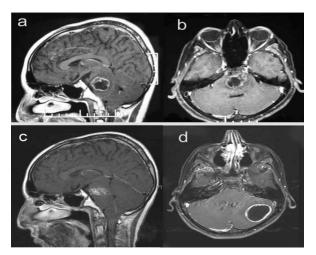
_Images before radiotherapy (a, b):Mid-sagittal (a) and axial (b) contrastenhanced T1-weighted MRIs show a lesion with wellcircumscribed heterogeneously contrast enhancement which was 30 mm in diameter. Images obtained 11 monthsafter radiotherapy (c, d): Mid-sagittal (c) contrastenhanced T1-weighted MRI shows the initial lesion which reduced significantly in size. Axial contrastenhanced T1-weighted MRI (d) shows a novel peripherally enhanced heterogeneous lesion with 30 mm in diameter on the left cerebellar hemisphere.
